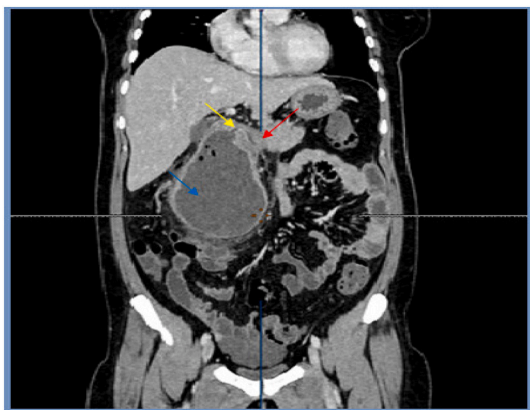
CT scan view showing a hydatid cyst with an exovesiculation of 20 cm in the lower pole. A fistulous communication (yellow arrow) between the duodenal bulb (red arrow) and the hydatid vesiculation (blue arrow). (For interpretation of the references to colour in this figure legend, the reader is referred to the web version of this article.)
